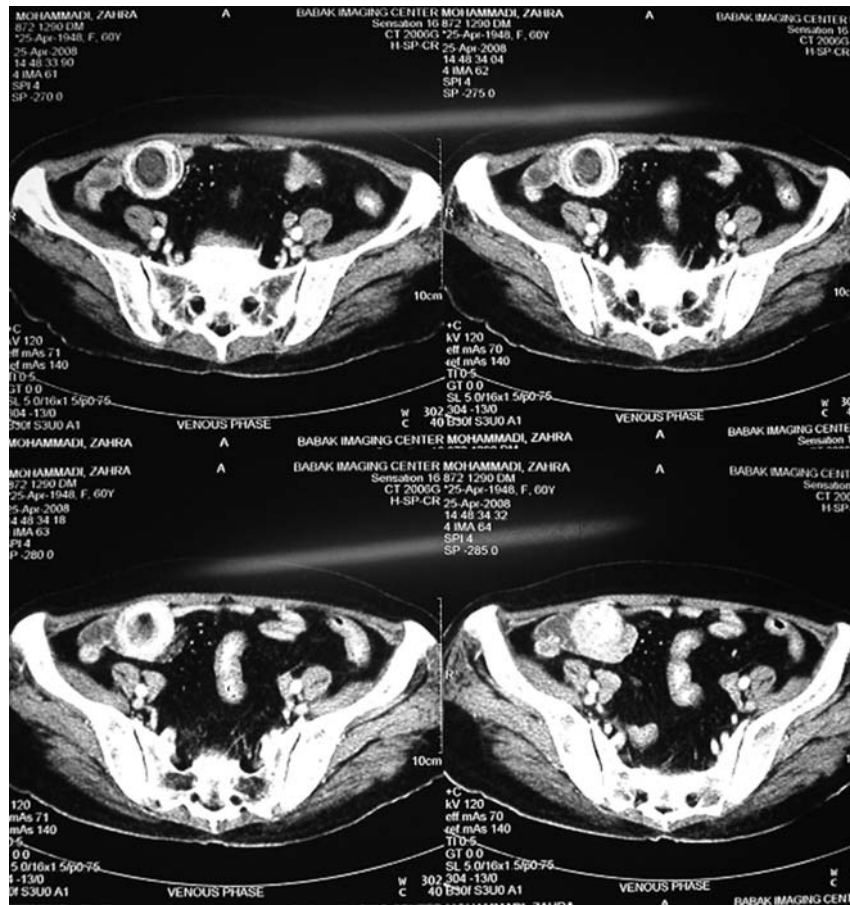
A CT Scan showing gall stone in ileum.
